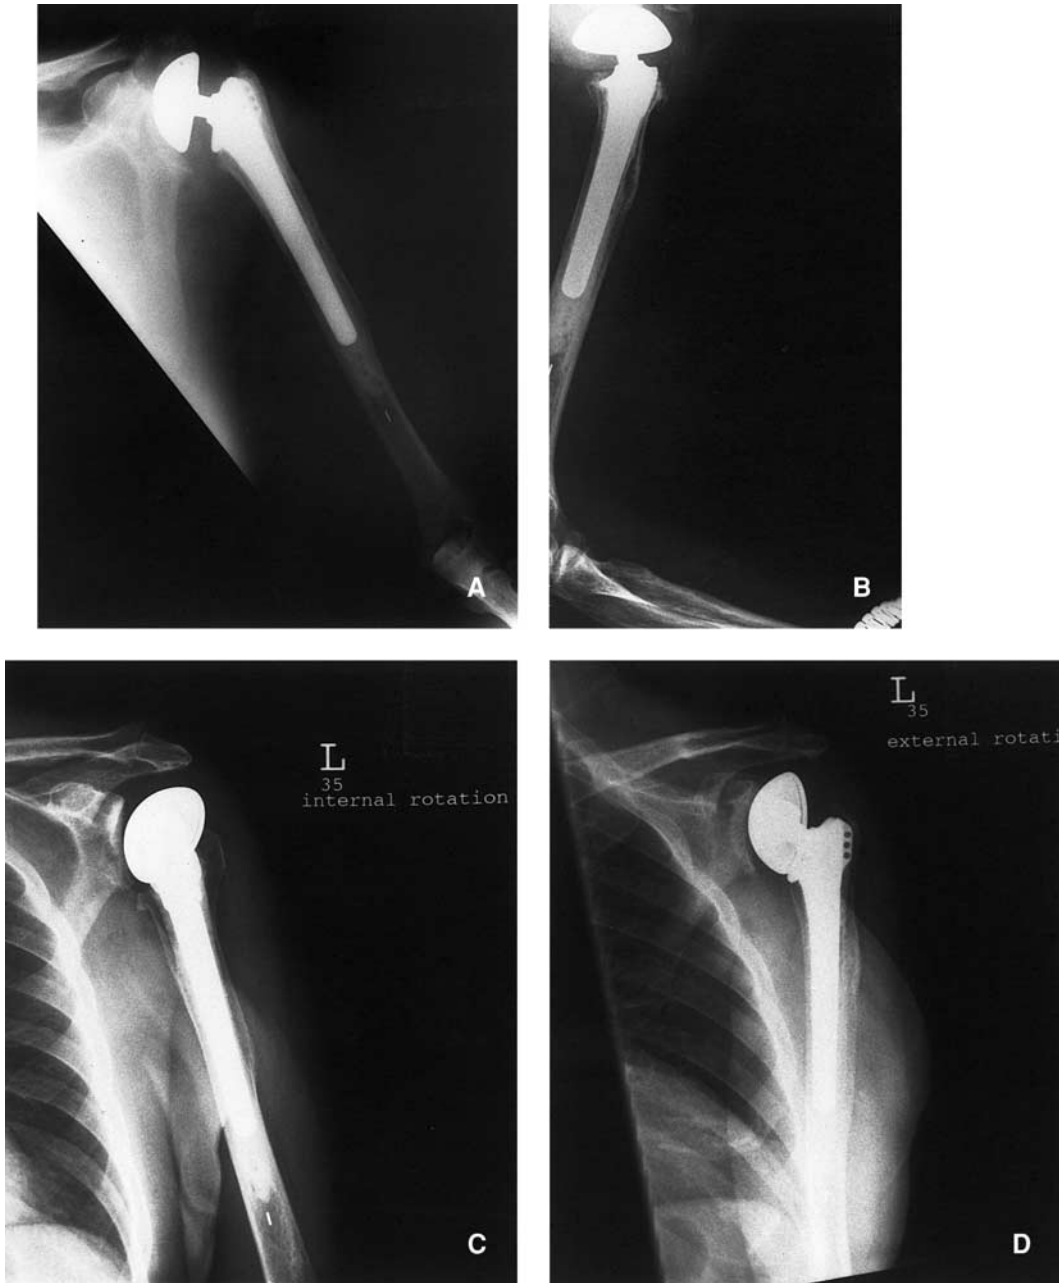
One-year follow-up included (A) anteroposterior, (B) lateral, and (C, D) rotational radiographs of the shoulder joint.
